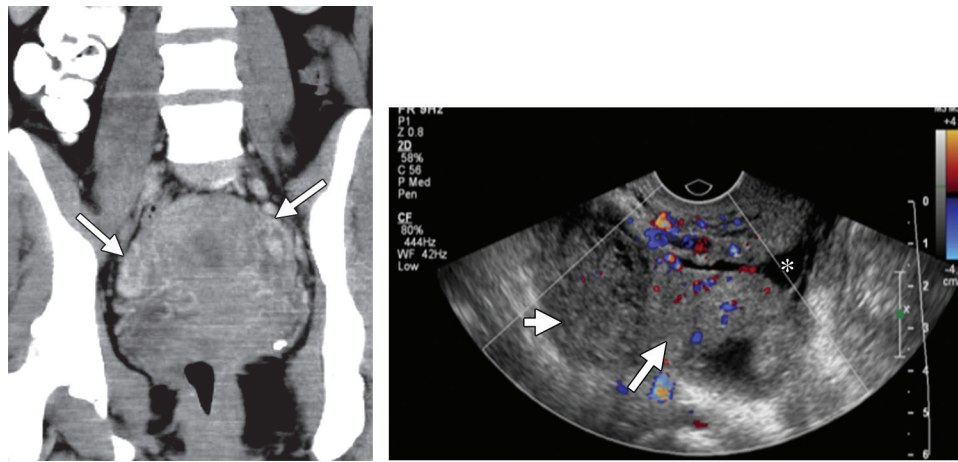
Early PID: salpingitis in a 19-year-old woman presenting with lower pelvic pain, leukocytosis, and fever. (a) Coronal contrast-enhanced CT image shows prominent abnormally enhancing fallopian tubes (arrows) bilaterally. (b) Transverse transvaginal color Doppler US image of the right adnexa obtained 2 days later shows a thick-walled hyperemic fallopian tube (long arrow), as well as the adjacent right ovary (short arrow) and a small amount of free fluid (*) in the adnexa.
